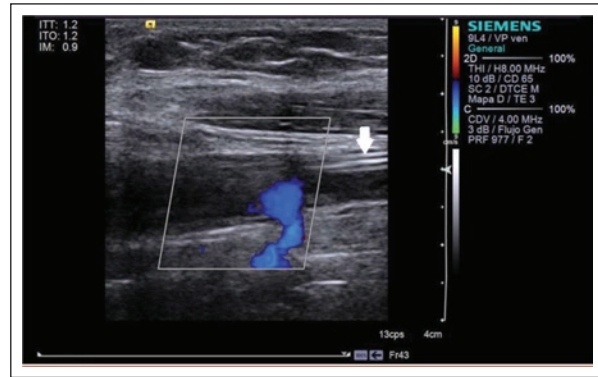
Color Doppler US of a 75-year-old male patient with COVID-19. The right upper extremity veins show acute deep PICC-ASVT, the catheter tip (white arrow), and partial blood flow occlusion in the right subclavian vein.
